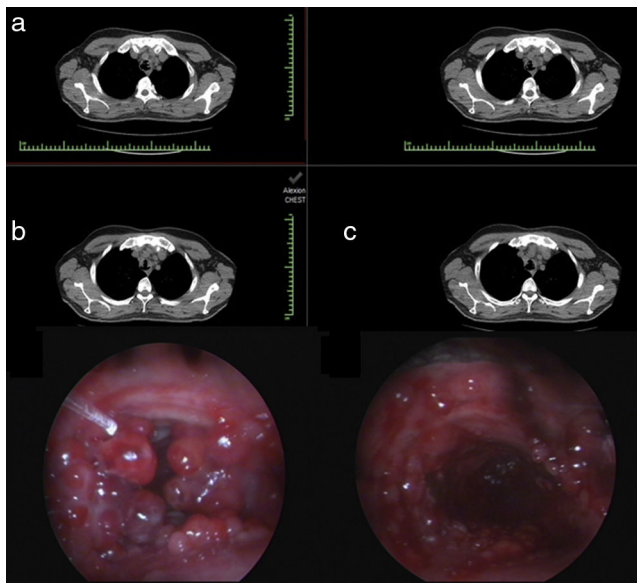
Tracheal lesions on the thorax computed tomography of the patient (a) Endobronchial view before (b) and after treatment (c).
